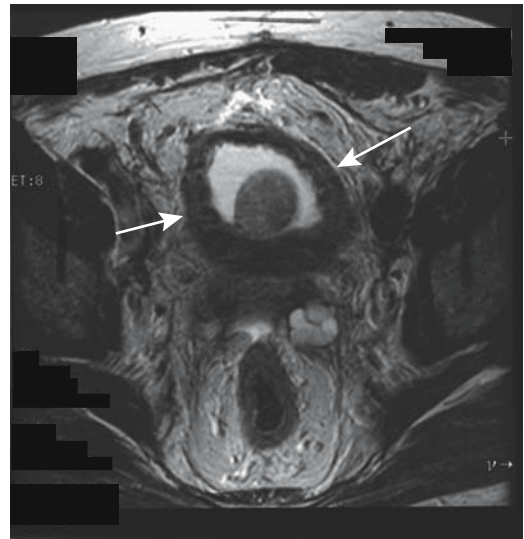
Benign prostatic hypertrophy, bladder outlet obstruction, and thick bladder wall (arrows), detected on T2-weighted magnetic resonance (MR) image. (Source: Burgener FA, Meyers SP, Tan RK, Zaunbauer W. *Differential Diagnosis in Magnetic Resonance Imaging*. Stuttgart: Thieme, 2002, with permission.)
